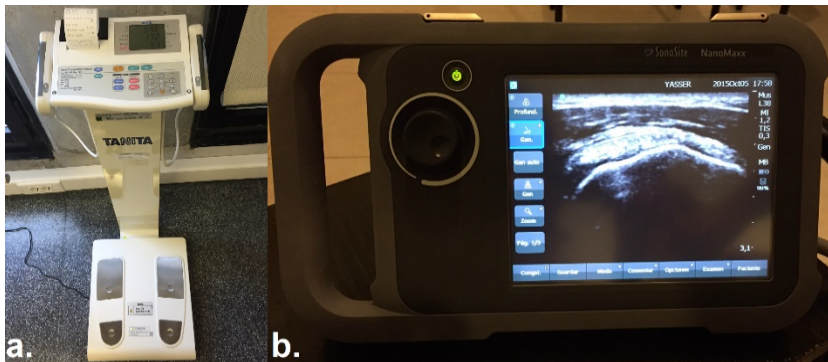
(a) Body composition analyzer: TANITA model BC 418 MA, (b) Portable touchscreen ultrasound system: NanoMax by FUJIFILM SonoSite with Color Power Doppler technology for high quality diagnostic imaging.
